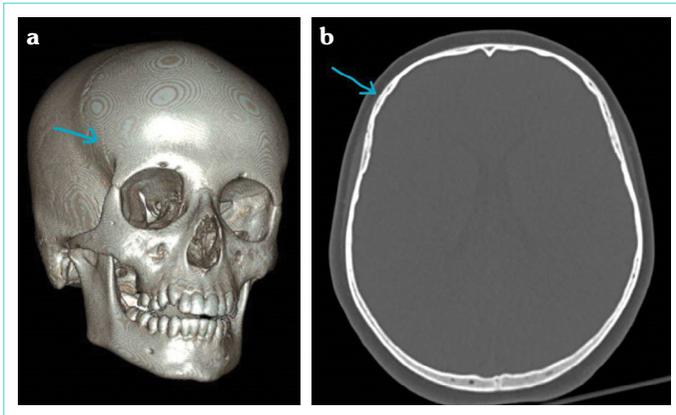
(a) 3-D reconstructed view of the cranial fracture in the temporofrontal region. (b) Fracture line which can be easily skipped unless an axial CT scan is carefully evaluated
